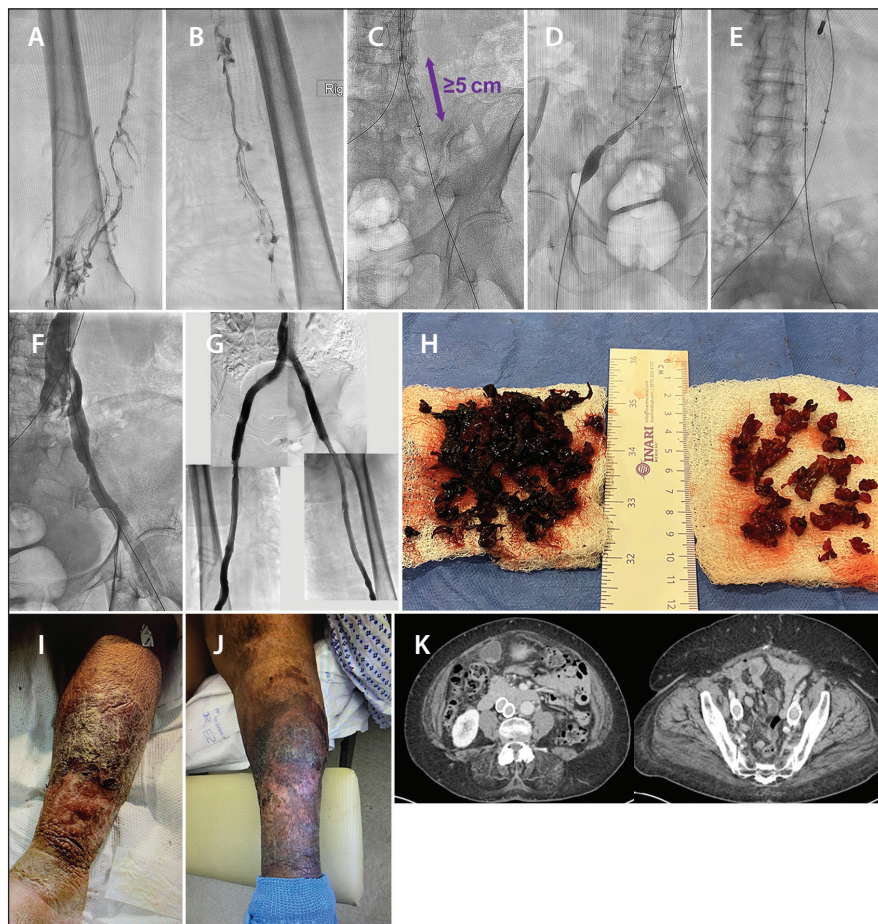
Preprocedure bilateral venograms taken in the prone position confirmed occlusive thrombus from the popliteal through the FVs on the left (A) and right (B). A ClotTriever catheter was advanced into the infrarenal IVC and stopped 5 cm below the tip of the right IJ sheath (C). Venoplasty of the lower IVC and left iliac vein revealed a tight waist on the balloon, indicating presence of chronic thrombus (D). “Dueling” ClotTriever catheters engaged the walls of the inferior IVC (E). Repeat venograms of the left lower extremity demonstrated a patent PV, FV, and CFV, with residual nonocclusive thrombus seen in the CFV, CIV, and lower IVC (F). After thrombectomy, brisk in-line flow and washout were seen throughout the bilateral lower extremities and into the IVC (G). Thrombus extracted from the bilateral iliofemoral veins and IVC (H). Compared to venous ulcer images taken preprocedure (I), significant improvement was seen 1 week postprocedure (J). Ultrasound (images not shown) and CT venograms confirmed sustained patency in the lower extremity vessels and ilio caval stents at 1.5 years postprocedure (K).
